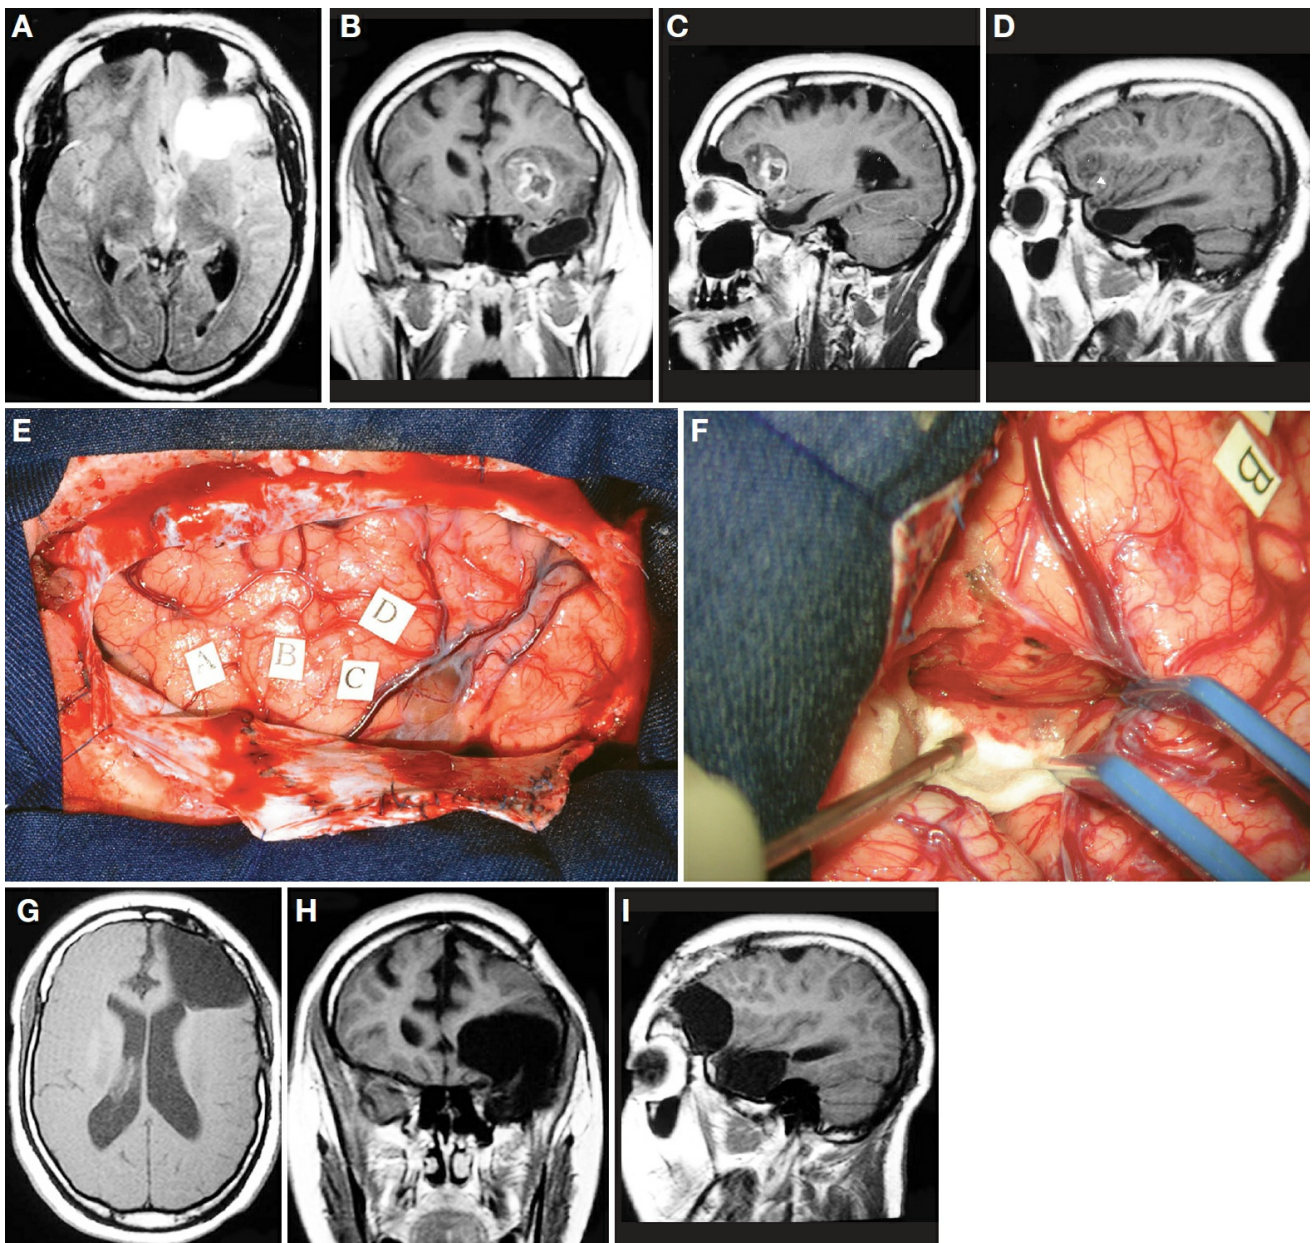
A, axial MRI scan depicting a left frontal tumor. B, coronal MRI scan. C, sagittal MRI scan depicting a tumor arising from the frontobasal region. D, sagittal MRI scan. The arrowhead indicates the anterior insular cleft. The tumor is confined in the fronto-orbital area. E, intraoperative photograph after a left pterional craniotomy and dural opening. The letters indicate epileptiform spikes in the left frontal lobe. F, intraoperative photograph showing the opening of the anterior insular cleft. The anterior surface of the insula was covered by the cottonoid. G, postoperative axial MRI scan. H, postoperative coronal MRI scan. I, postoperative sagittal MRI scan. The mediotemporal structures also were removed. (Images courtesy of AL Rhoton, Jr.)
